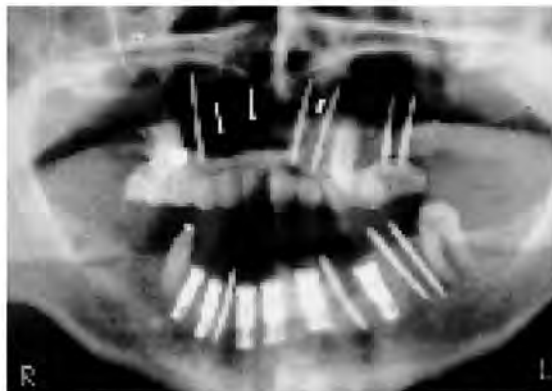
Postsurgical panoramic radiograph immediately after initial surgery.
